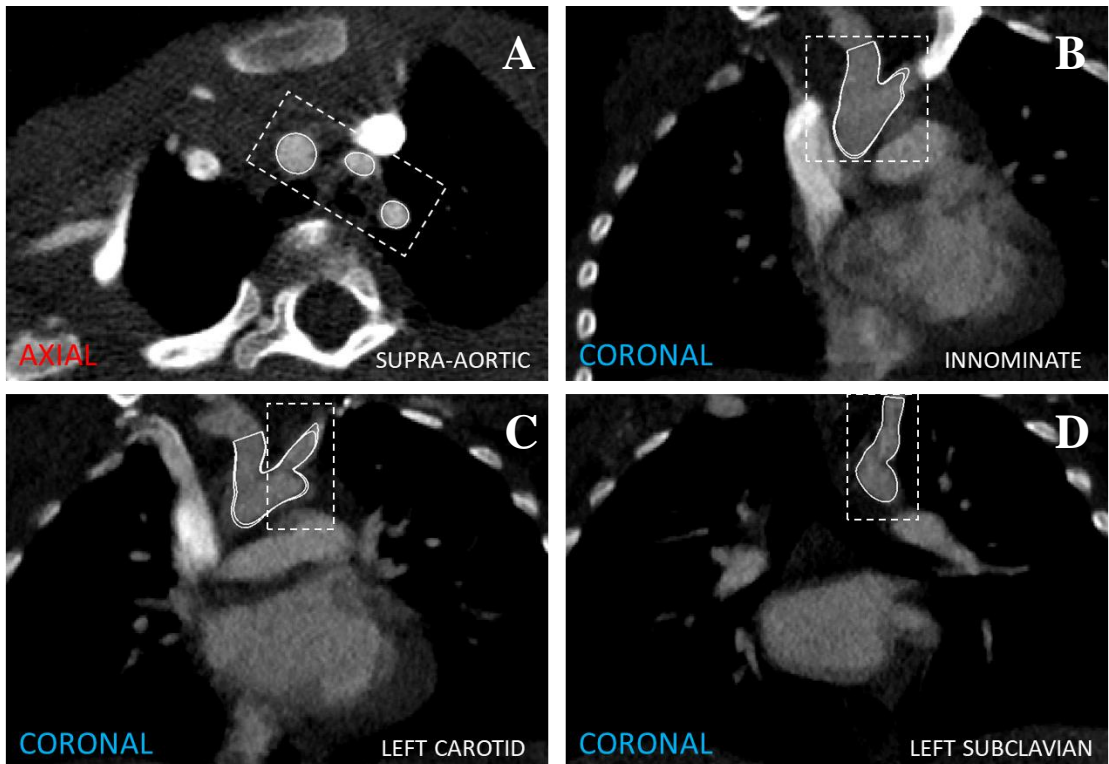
Superposition of the segmented surfaces of the supra-aortic vessels and the transverse aortic arch onto the CTA images showing the surface from a coronal and axial view
